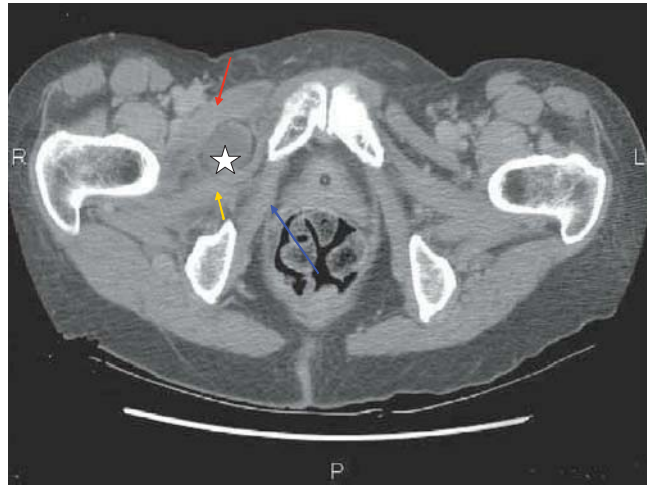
Axial CT demonstrating a herniated small bowel loop (*white star*) located between the right pectineus muscle (*red arrow*) anteriorly and the right obturator externus muscle (*yellow arrow*) posteriorly. The internal obturator muscle is shown with a blue arrow.
